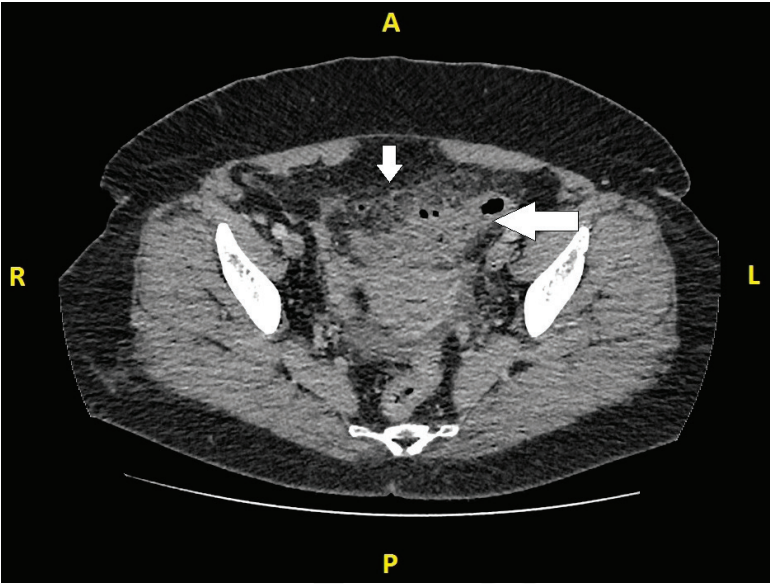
Computed tomography scan demonstrates infiltration of the fat surrounding the sigmoid colon (small arrow) whose wall is thickened and irregular (big arrow).
